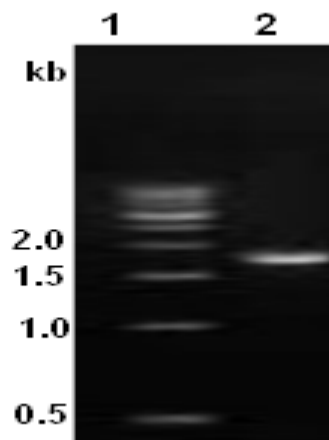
6 RT-PCR amplification of CAT1 cDNA. *Lane 1* 1 kb DNA ladder; *Lane 2* RT-PCR product (~1.6 kb) using total RNA from the growing potato tuber of the cultivar KC-1 and the CAT cDNA-specific primers, F1-CT 0001 and R2-CT1600
